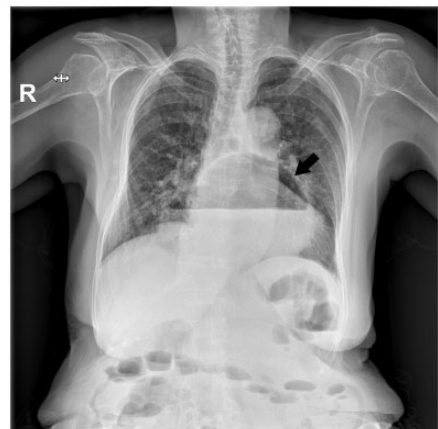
Preoperative chest X-ray shows a giant hiatal hernia (black arrow)
